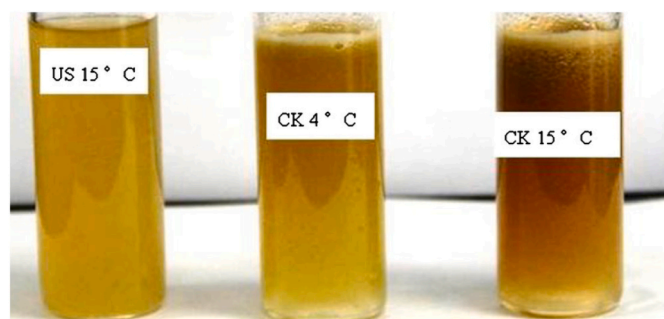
Ultrasonically (US) treated fresh apple juice at 15 °C and control check (CK) at 4 and 15 °C (Sun et al., 2015).
